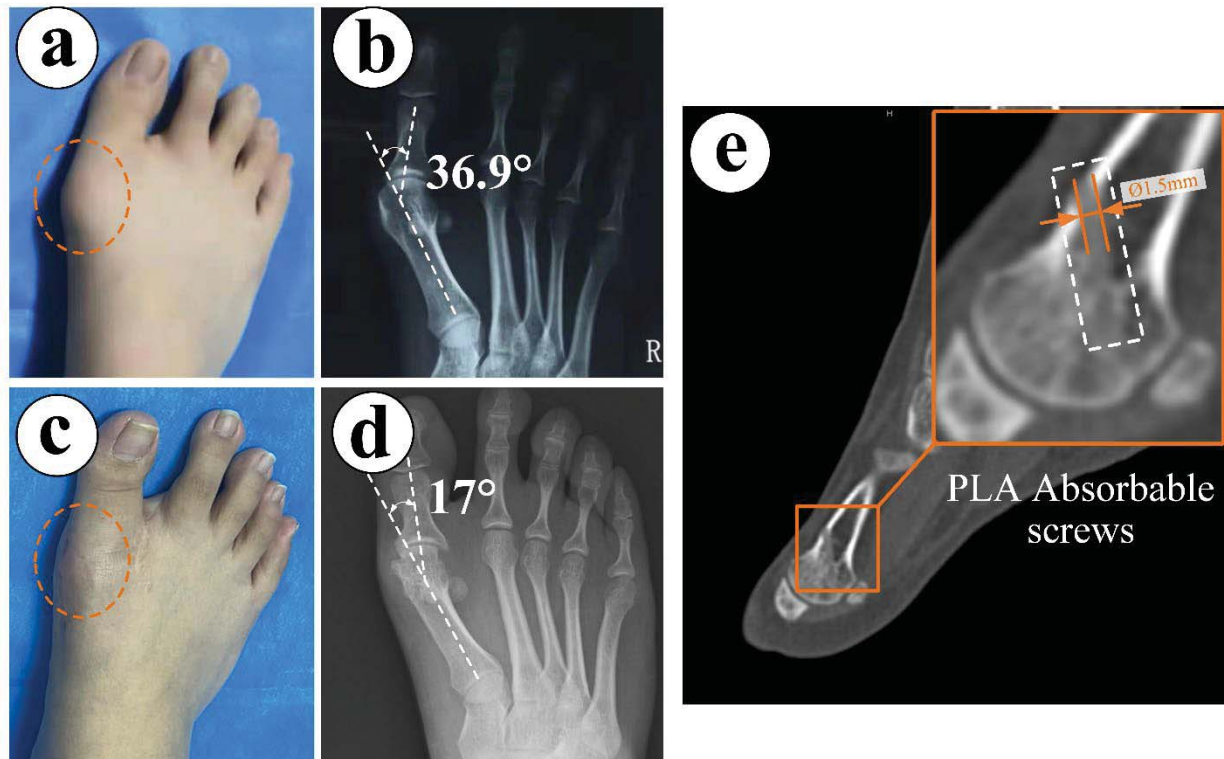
A 21-year-old female with right foot HV deformity. a. Preoperative image ; b. Preoperative anteroposterior X-ray; c. Image at 24 months after surgery; d. Anteroposterior X-ray at 24 months after surgery; e. CT scan at 24 months after surgery showed that the diameter of bioabsorbable screw was about 1.5mm
